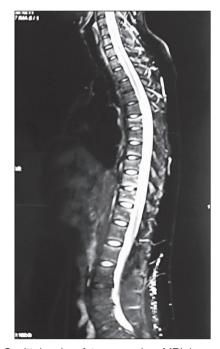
Sagittal spine fat supression MRI image of patient before the vertebroplasty procedure (patient no 4).
